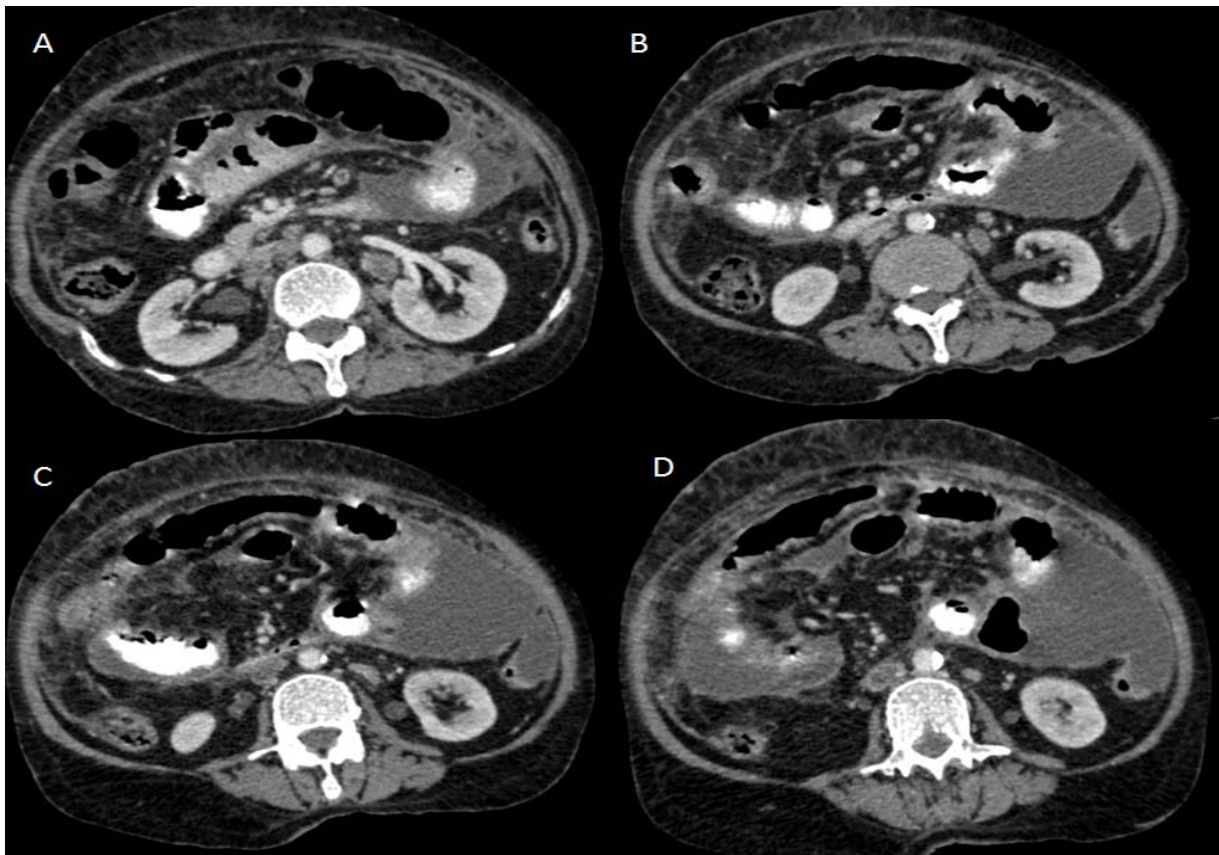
Contrast-enhanced CT scan of the abdomen showing lymph nodes at left para-aortic and inter-aortocaval region (A, B), a filling defect in IVC suggestive of IVC thrombosis (C, D).
